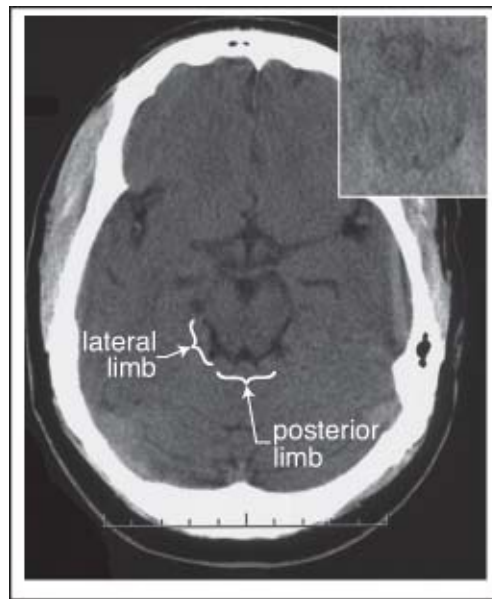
Basal cisterns CT demonstrating open basal cisterns (inset: example of \approx complete obliteration of BCs)
